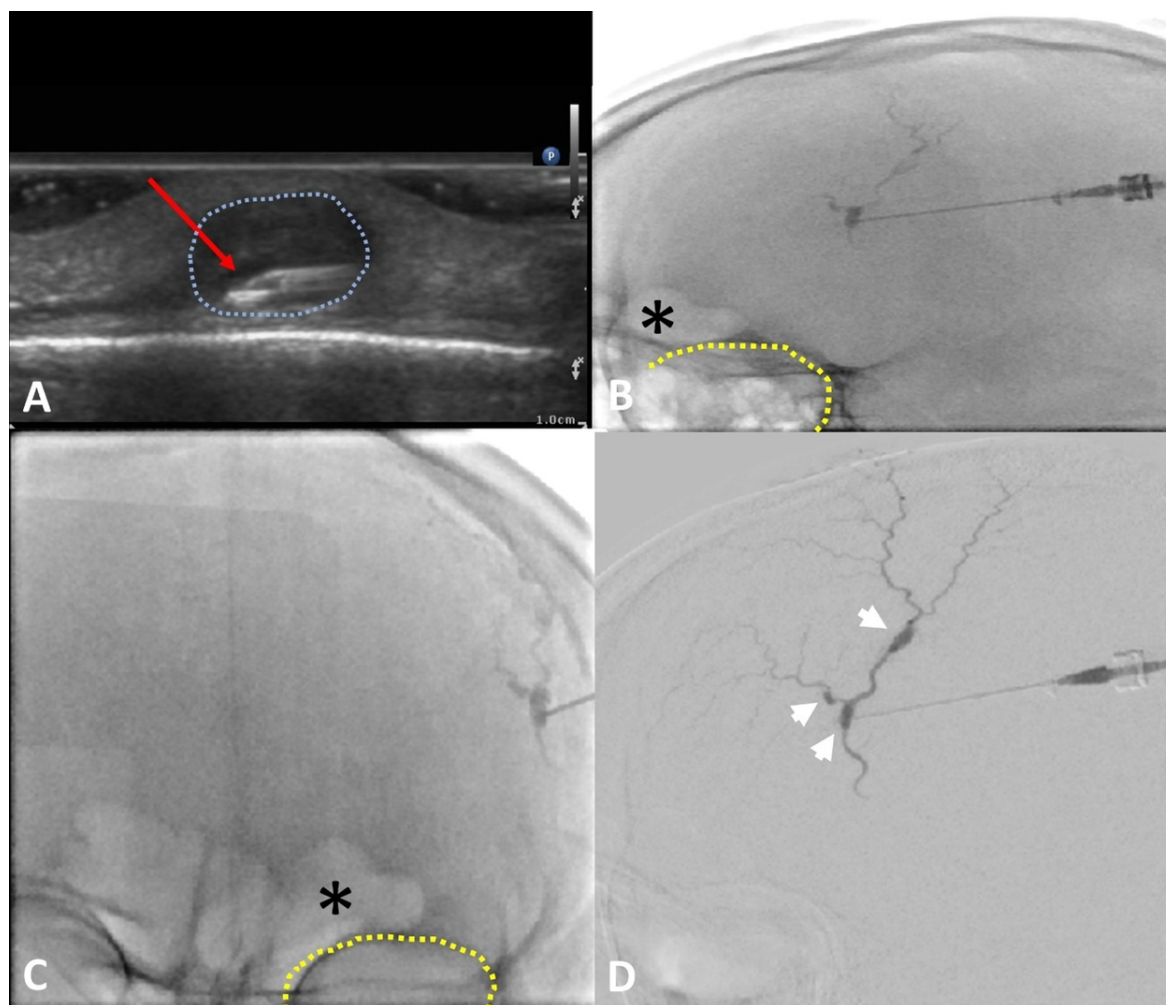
IR Intervention. A: Ultrasound image showing percutaneous 21G needle access (red arrow) into the pseudoaneurysm (blue perforated circle). B: Lateral projection fluoroscopic spot image showing the percutaneous needle within the pseudoaneurysm after injection of iodinated contrast. Moreover, the left frontal sinus (*) and left orbit (yellow perforated circle) are depicted for relative positioning of the needle access. C: An anteroposterior projection fluoroscopic spot image showing the relative position of the left frontal sinus (*) and left orbit (yellow perforated circle). D: Three pseudoaneurysms (white arrowheads) arising from parent superficial temporal artery are confirmed during digital subtraction angiography achieved through percutaneous needle access into one of the pseudoaneurysms.
